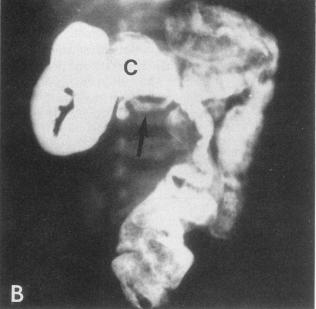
(A) Plain film of the abdomen showing a dilated stomach with mild duodenal dilatation. Note the paucity of gas distal to the duodenum. S, stomach; D, duodenum. (B) Barium enema study showing malposition of the cecum. C, cecum; *arrow*, appendix.
